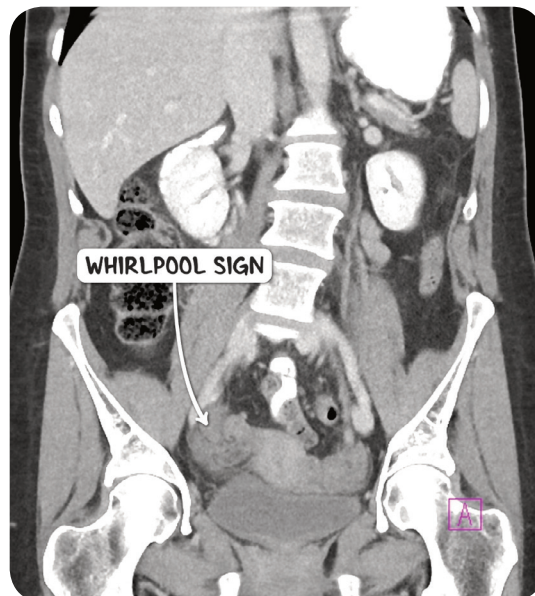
A CT scan of the abdomen and pelvis in the coronal plane demonstrating whirlpool sign in an individual with torsion of the right ovary.
